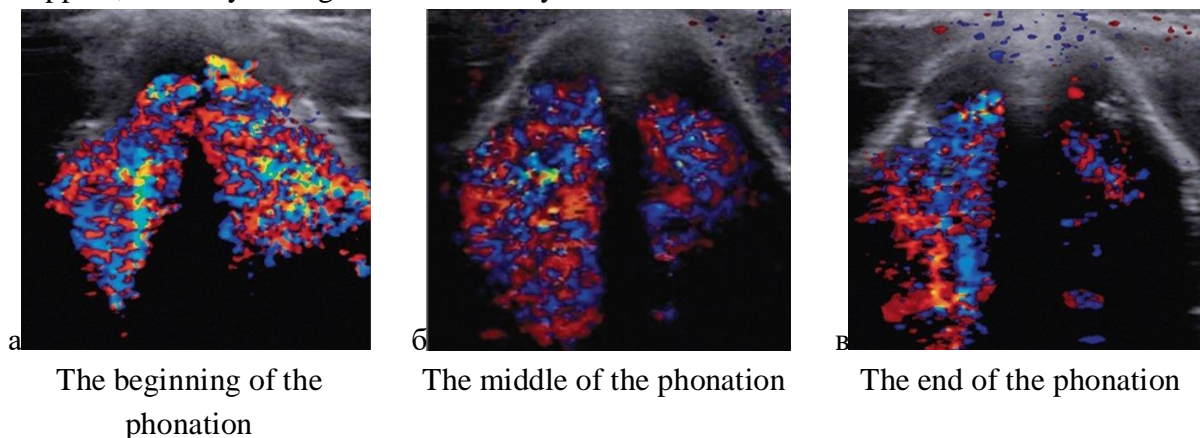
Sequence of images in Doppler mode with functional dysphonia
